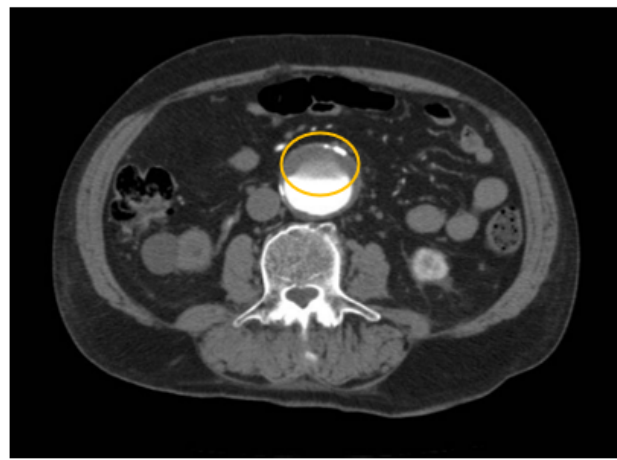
Angio CT revealed marked atherosclerotic plaques in the abdominal aorta with a mural thrombus.
